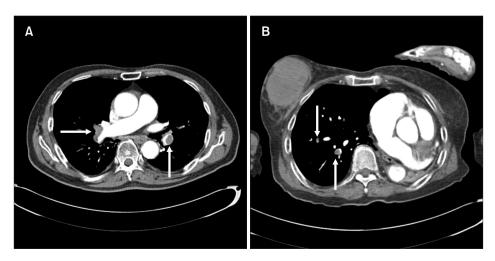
Computed tomography angiograms of patients with pulmonary embolism (PE). (A) Bilateral PEs in the lobar arteries (arrows). (B) PE in the right segmental pulmonary arteries (arrows).
